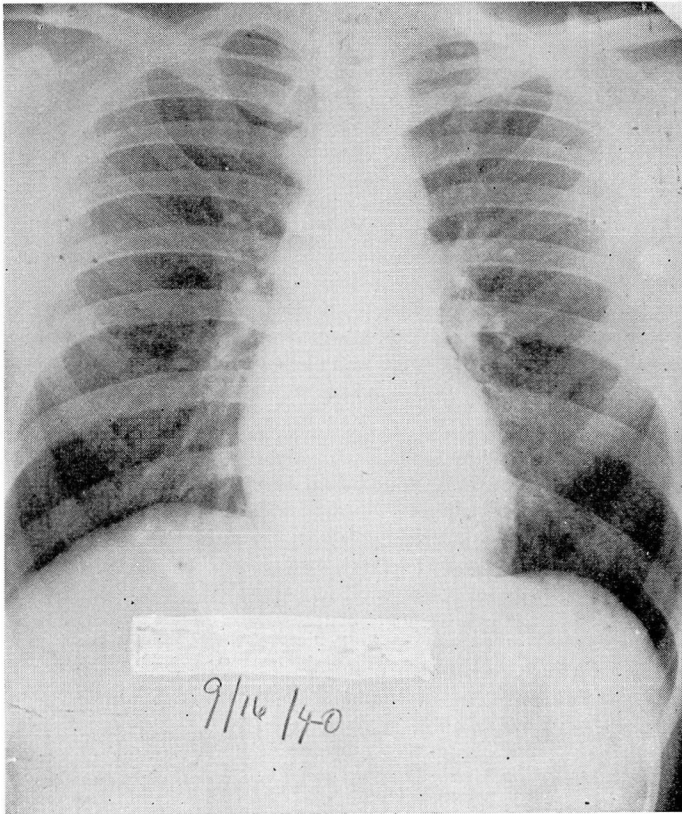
X-ray of the chest taken on admission on 9/16/40. This was interpreted as being essentially normal save for rather heavy hilar shadows. The sedimentation rate was rapid, and the Weltmann coagulation band = 4.
